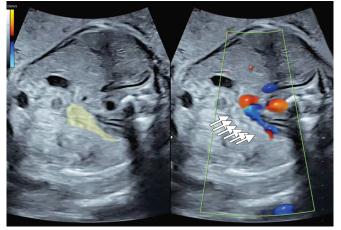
Image at 27 weeks of gestation. The left image was obtained in B mode; the pancreas is located in the yellow-shaded area. The right image was obtained in color Doppler mode; the spleen blood vessels are visualized. The pancreas (arrows) is located ventral to the splenic blood vessels
